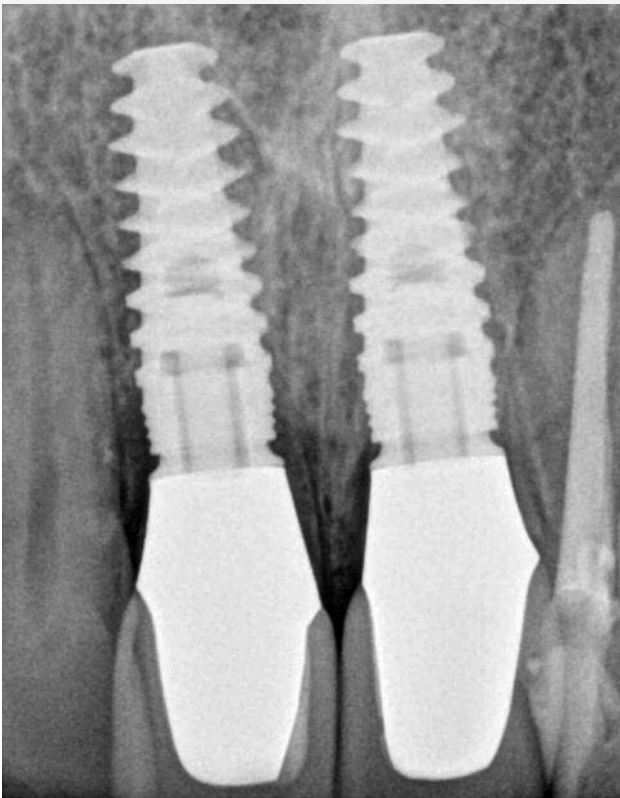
Periapical view of the implant restorations at the 2-year follow-up
